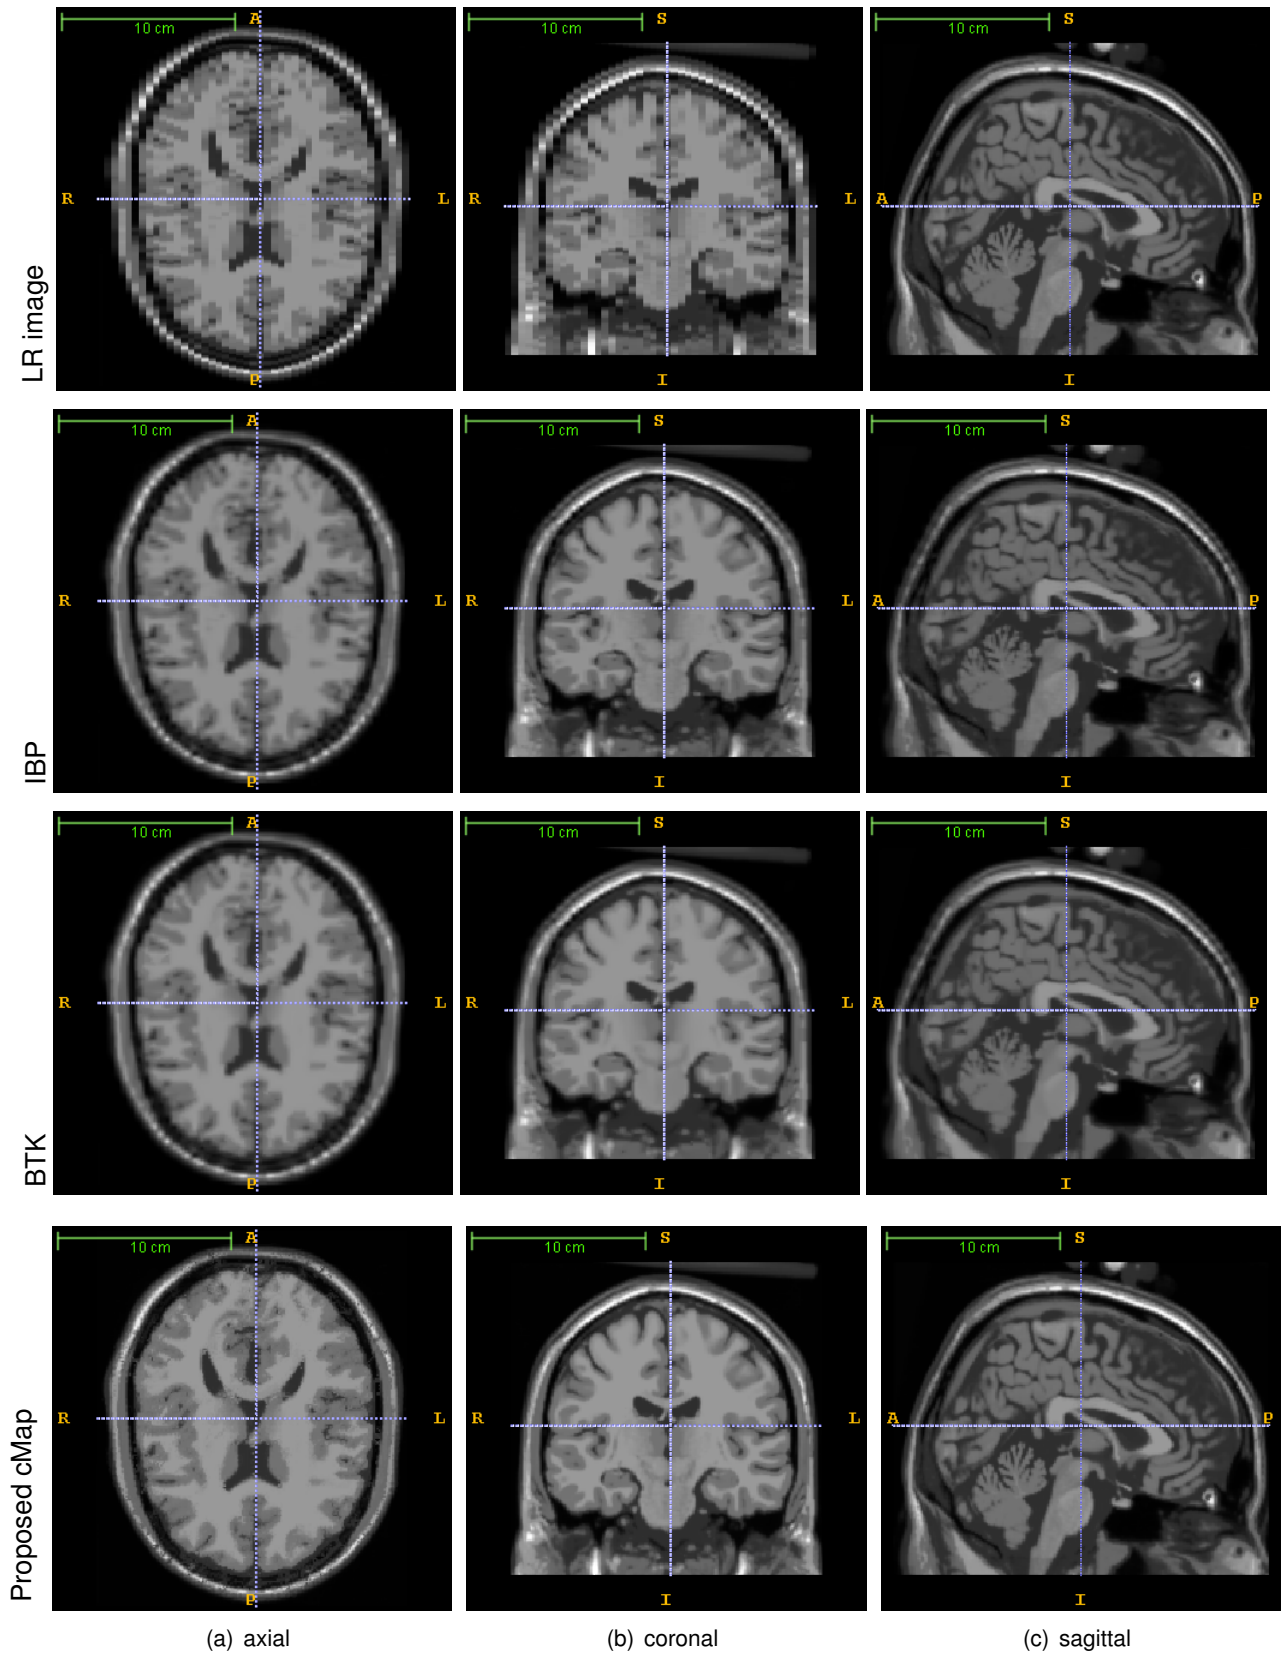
Axial, coronal, and sagittal views of one LR MR image and the appropriate views of reconstructed images.
